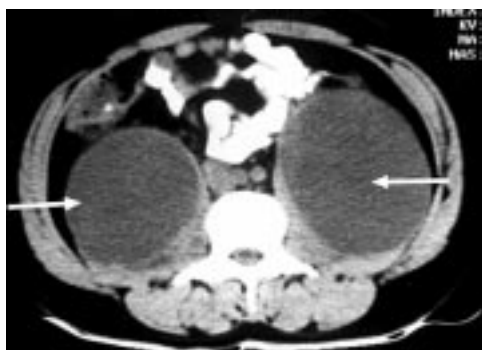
Computed tomography of the abdomen showing bilateral, rounded, hypodense lesions within the psoas sheath (arrows). Note curvilinear compression of psoas muscles on both sides.
